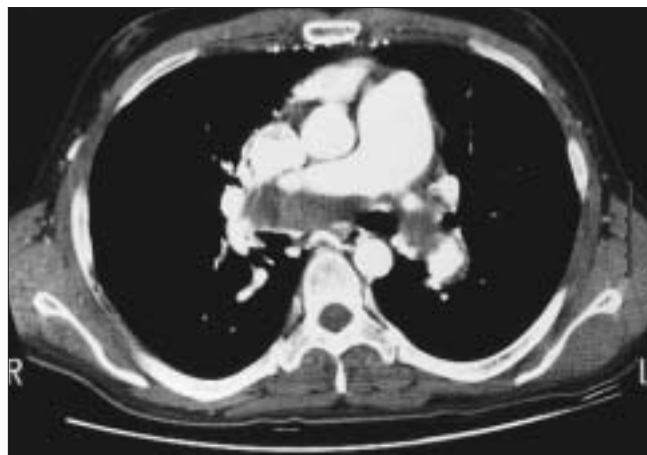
Computed tomographic angiogram in a patient with CTEPH showing partially organized thrombus lining both right and left pulmonary arteries, with narrowing of the right main pulmonary artery at the origin of the upper lobe. Asymmetric wall thickening is also evident along the lateral aspect of the left descending pulmonary artery. (With permission from LEWIS J. RUBIN)
